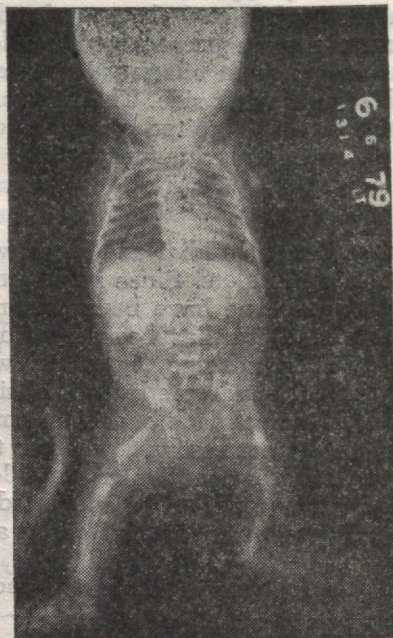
X-ray showing bilateral absence of radius and ulna, absent femur on left side and bifid vertebral bodies.
